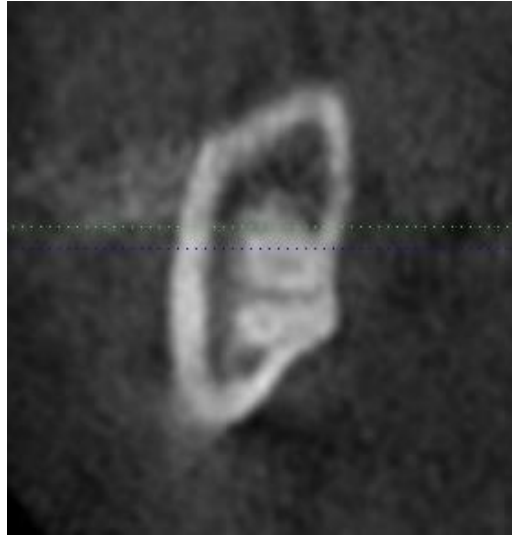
Reformatted panoramic CBCT image demonstrating loss of the cortical boundary of the mandibular canal in relation to the impacted right mandibular third molar. The reformatted cross sectional CBCT image displays proximity of the roots of tooth #48 to the mandibular canal (arrow).
